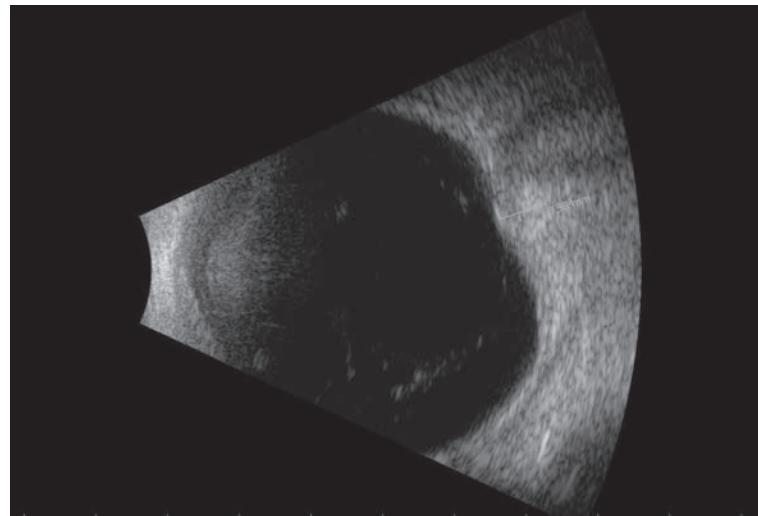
B-scan ultrasonography of the left eye showing a convex, echodense elevation of the posterior pole, measuring 3.38 mm in thickness.
